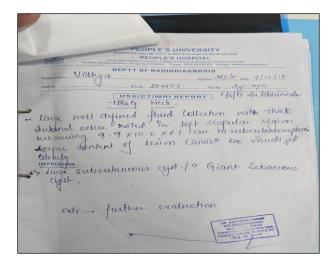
Ultrasound showing giant epidermal cyst in the subcutaneous plane of the right upper back.
